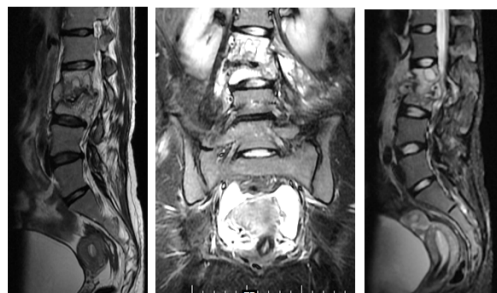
19 year old adolescent girl presented with fever, pain and swelling in the lower back for 1 week. A) Sag T2WI B) Coronal STIR MR images shows, Abnormal T2 and STIR high signal intensity is seen involving L2, L3 vertebral body with involvement of disc vertebral complex with destruction of the vertebral bodies and endplates predominantly involving L3 causing 70-80 % reduction in the vertebral height with mild retropulsion of the L3 vertebrae indenting the anterior thecal sac.
